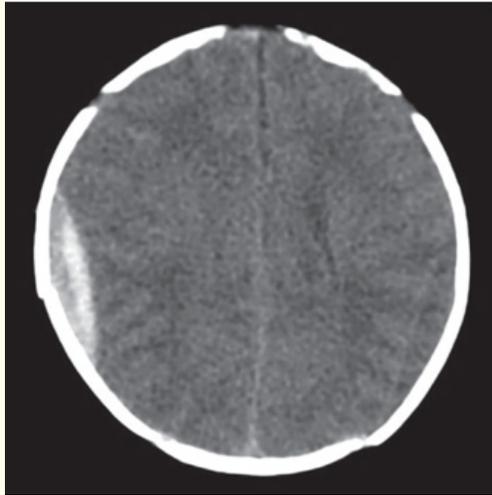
CT scan of epidural bleeding of the neonate.
